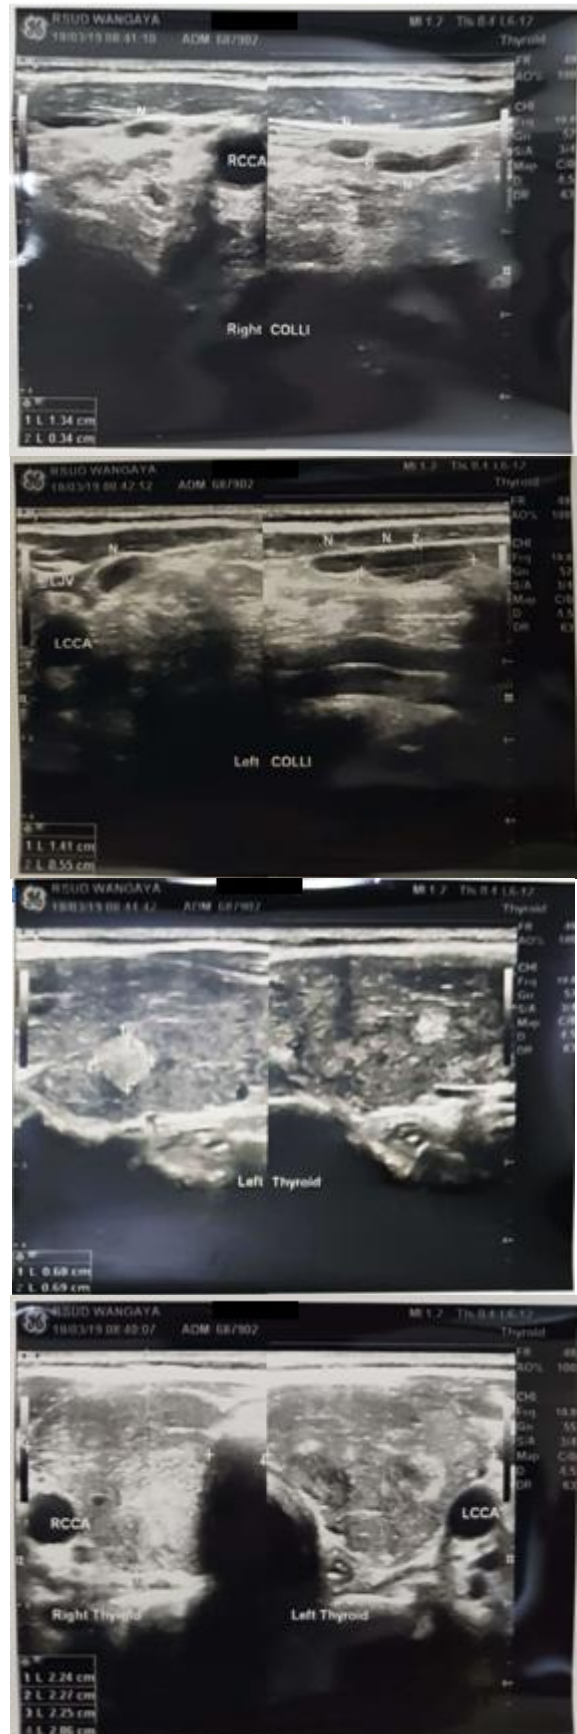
Thyroid ultrasound
